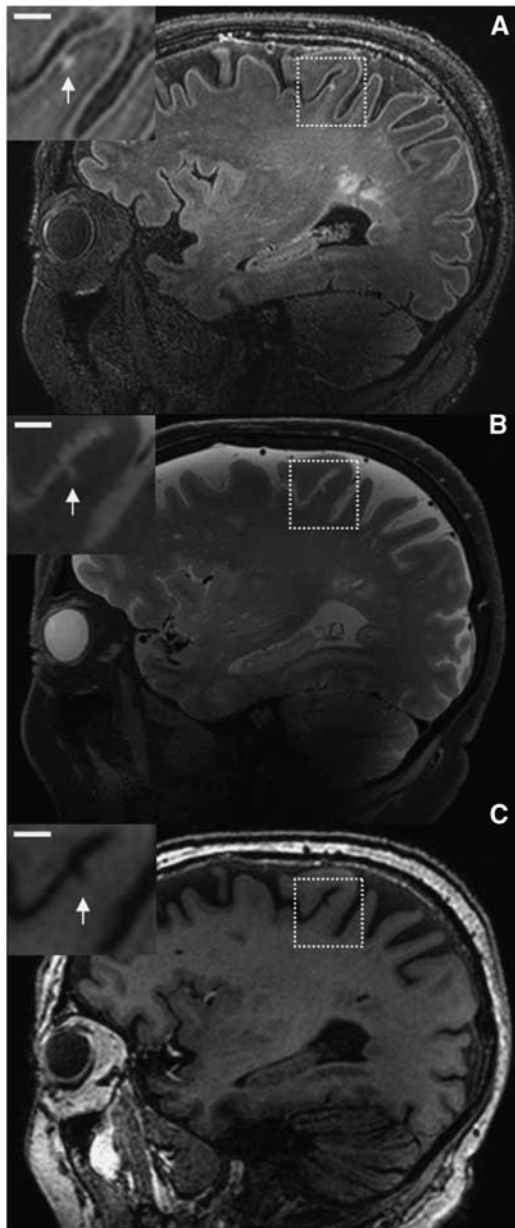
Possible cerebral microinfarct (CMI) at 7.0T *in vivo* magnetic resonance imaging (MRI). A possible cortical CMI in a 76-year-old nondemented male is represented as a hyperintense cortical lesion on a fluid attenuated inversion recovery (FLAIR) (A; $0.8 \times 0.8 \times 0.8$ mm³) and a T_2 weighted (B; $0.7 \times 0.7 \times 0.7$ mm³), and as a hypointense lesion on a T_1 weighted (C; $1.0 \times 1.0 \times 1.0$ mm³) magnetic resonance (MR) image on a sagittal view of the brain. Scale bar indicates 4 mm.
